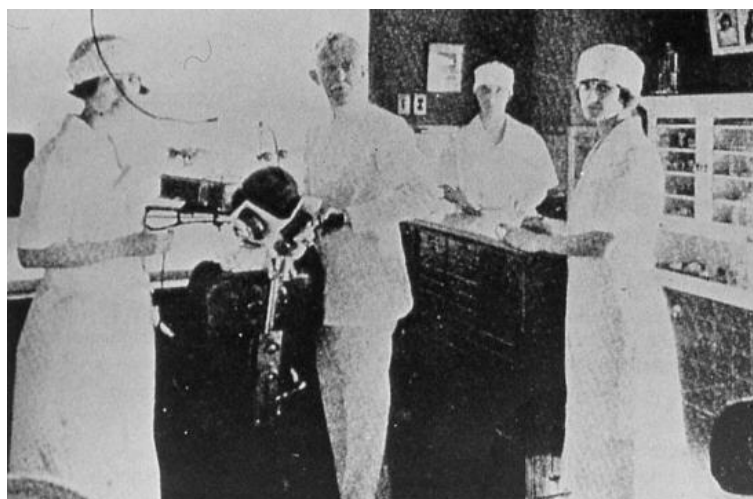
C.E. Kells at work; one can notice the damage to his left hand caused by repeated X-ray exposure.
